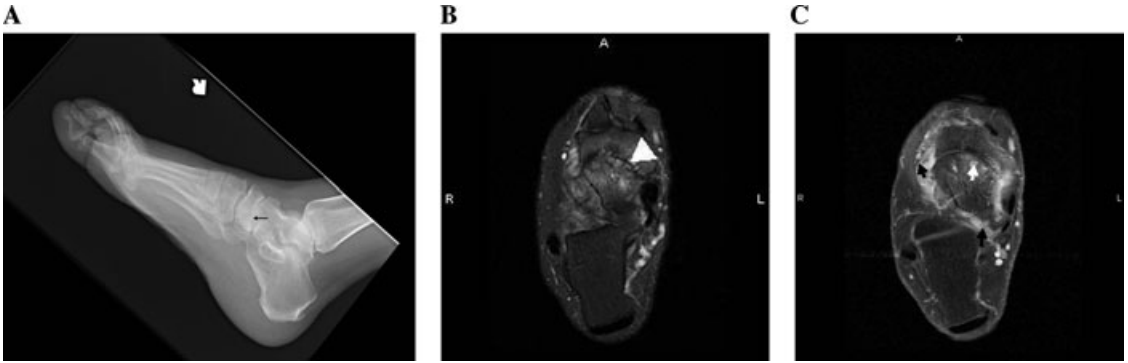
Lateral view (A) of the right foot of a 53-year-old woman with RA. The bones are osteopenic and there is joint space narrowing at the talonavicular joint (black arrows) without evidence of erosions. Axial T2 fast spin-echo images with fat saturation (B) and axial T1-weighted images with fat saturation and gadolinium contrast administration (C) were taken of the right ankle/hindfoot. Erosions are easily visualized at the talonavicular joint as focal areas of bright T2 signal (white arrowhead in B), and they enhance after contrast administration (white arrow in C). There is also enhancing rheumatoid pannus (black arrow in C).
